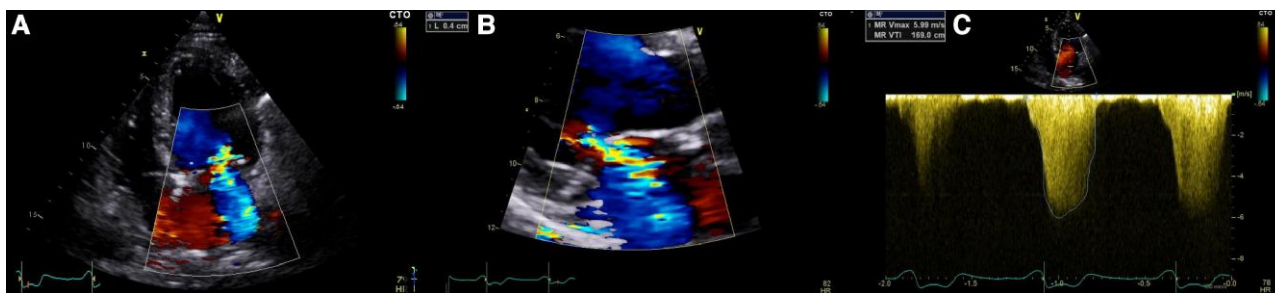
Transthoracic echocardiography performed on day 1 following permanent pacemaker implantation. Colour flow Doppler imaging in the (A) apical four-chamber and (B) parasternal long-axis views with vena contracta width of 0.4 cm. (C) Continuous wave Doppler profile of holosystolic mitral regurgitant jet but with a slightly incomplete Doppler envelope. Quantification by stroke volume method-confirmed moderate mitral regurgitation.
